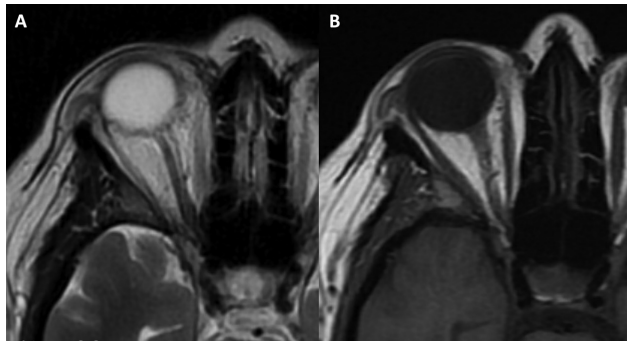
Follow-up magnetic resonance imaging (MRI) of the brain after 6 months. (A) An axial T2-weighted image and (B) axial T1-weighted MRI of the brain at the level of orbit show complete resolution of the retrobulbar hematoma.
